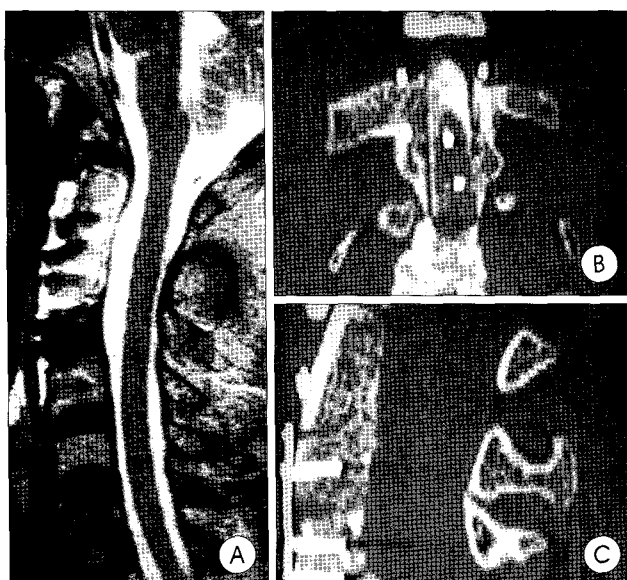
A : Postoperative magnetic resonance image demonstrate that the spinal cord is decompressed. B, C : Postoperative computed tomography scans show resection of C2 body and placement of graft following tumor mass removal.
